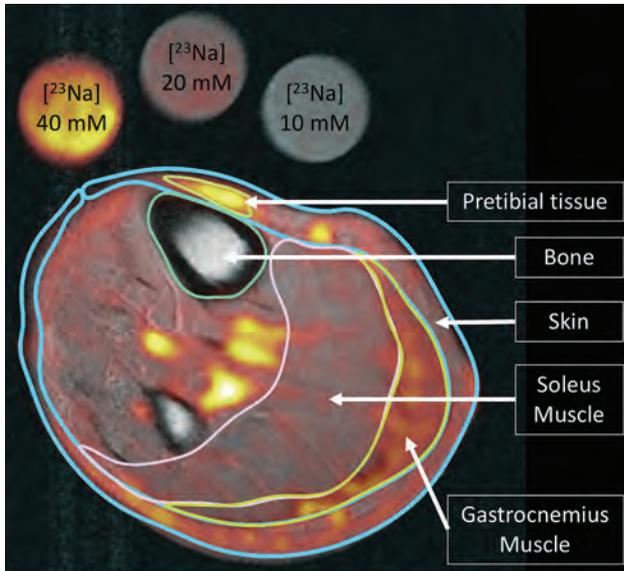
<sup>23</sup>Na MRI of lower leg superimposed over the corresponding anatomical proton MR image. The different tissues are represented by colored sections.
